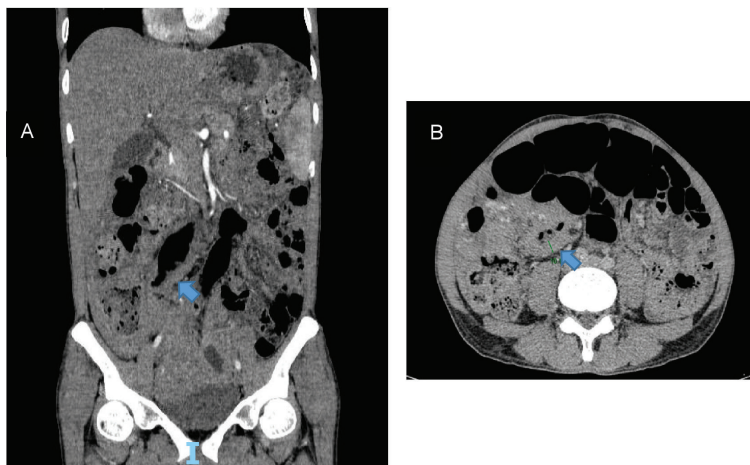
Contrast enhancement computed tomography in coronal (A), axial (B) shows the small bowel loops were dilated and the terminal ileum wall thickened
